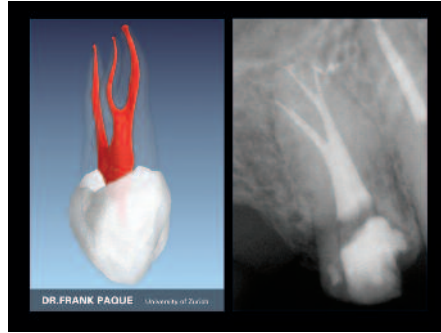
A μ CT image of a maxillary first bicuspid shows three systems and an anatomically broad isthmus between the buccal and lingual canals (courtesy of Dr Frank Paqué; Zurich, Switzerland). My posttreatment film reveals the buccal and lingual systems are joined by a deep and broad isthmus that extends to midroot. Note the buccal and lingual canals bifurcate at mid-root and the lingual system bifurcates in its apical one-third
